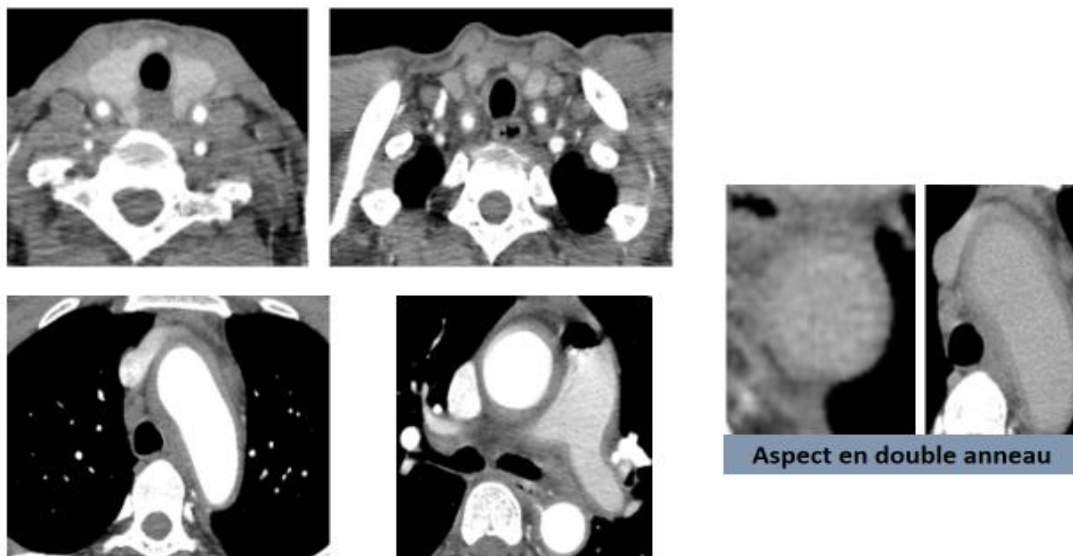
Thoracic CT angiography showing parietal thickening of the aortic wall with a double ring appearance.
